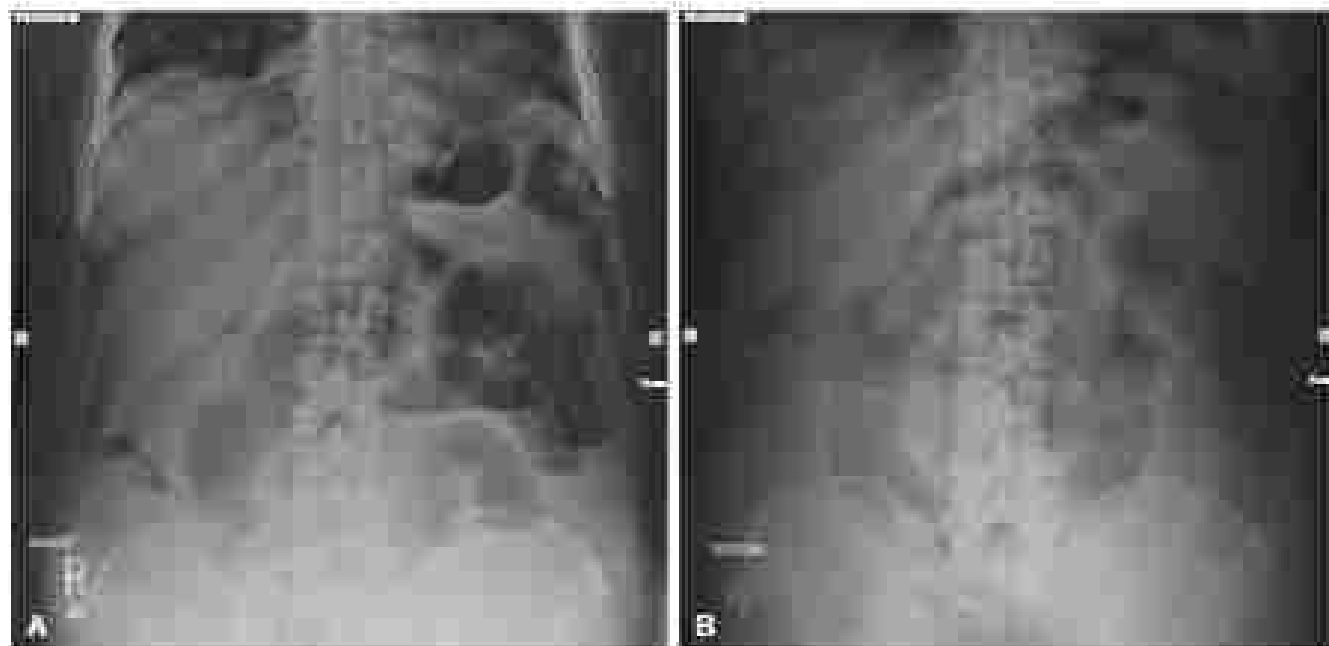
Plain abdominal upright radiograph of a patient with a complete small bowel obstruction. (A) Differential air-fluid levels and upright films. (B) Dilated loop of small bowel, with no retention of contrast gas.
